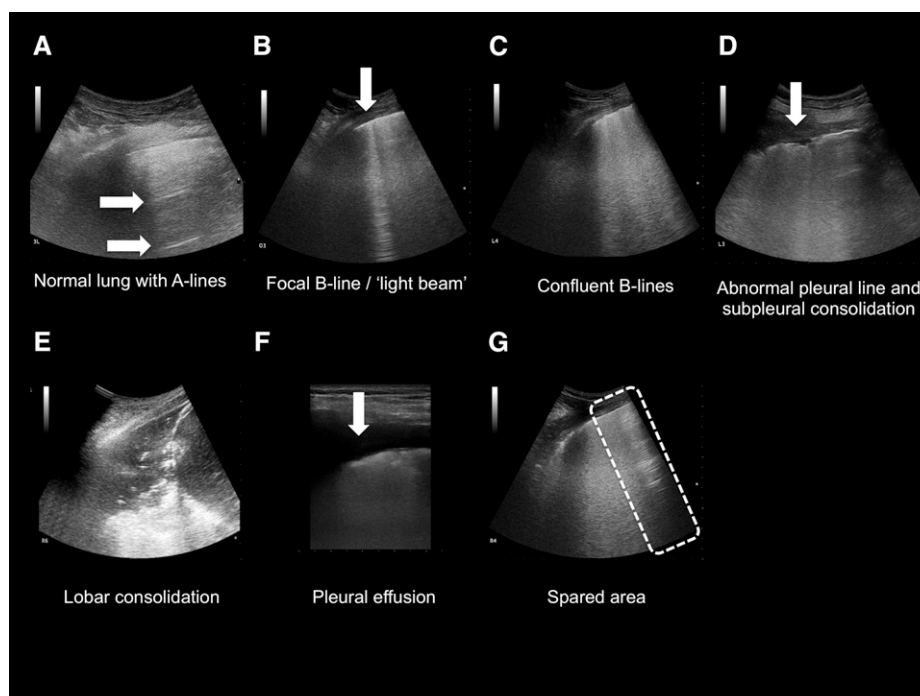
Common lung ultrasound patterns found in COVID-19. (A) Normal lung with A-lines, (B) focal B-line shown by arrow, (C) confluent B-lines with white lung appearance, (D) abnormal pleural line with small subpleural consolidation shown by arrow, (E) lobar consolidation, (F) pleural effusion indicated by arrow, (G) spared area indicated by dashed line. Source: Produced by Luigi Pisani; permission is granted for the reuse of this figure.
